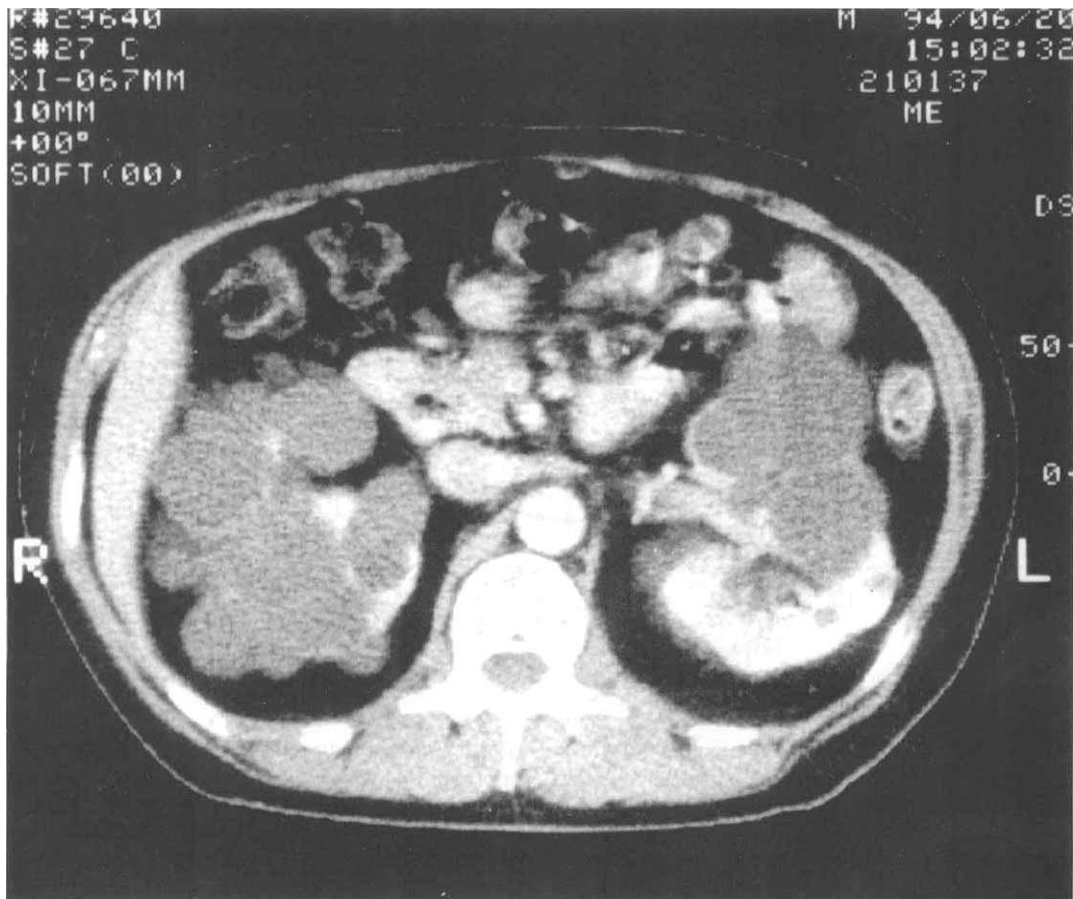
Abdominal CT scan showing extensive cyst formation in both kidneys.
